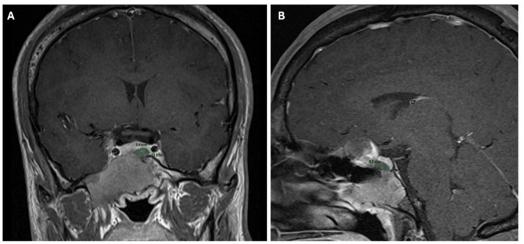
T1-weighted images of pituitary MRI at initial diagnosis. (A) coronal view showing T1-hypoenhancing 5.4 x 10.8 mm lesion. (B) Sagittal view of T1-hypoenhancing lesion with anterior-posterior diameter of 8.6 mm.
